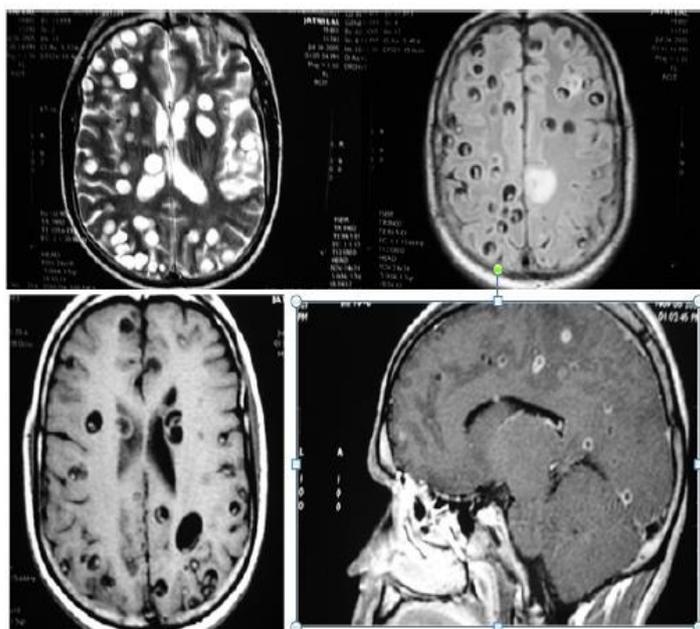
NCC in different MRI projection and sequences
